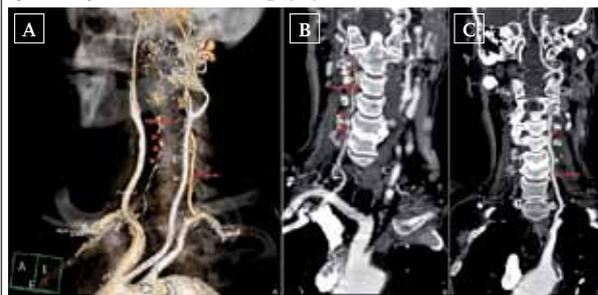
A: 3D VRT (Volume Rendering Technique)-reconstruction of CT-angiography showing multiple stenosis (red arrowheads) along the course of the right vertebral artery. B and C: oblique-coronal views of curved MPR's (multiplanar reformatting) showing multiple stenoses (red arrowheads) along the course of the right vertebral artery (B) and a mild stenosis (red arrowhead) of the left vertebral artery (C)
